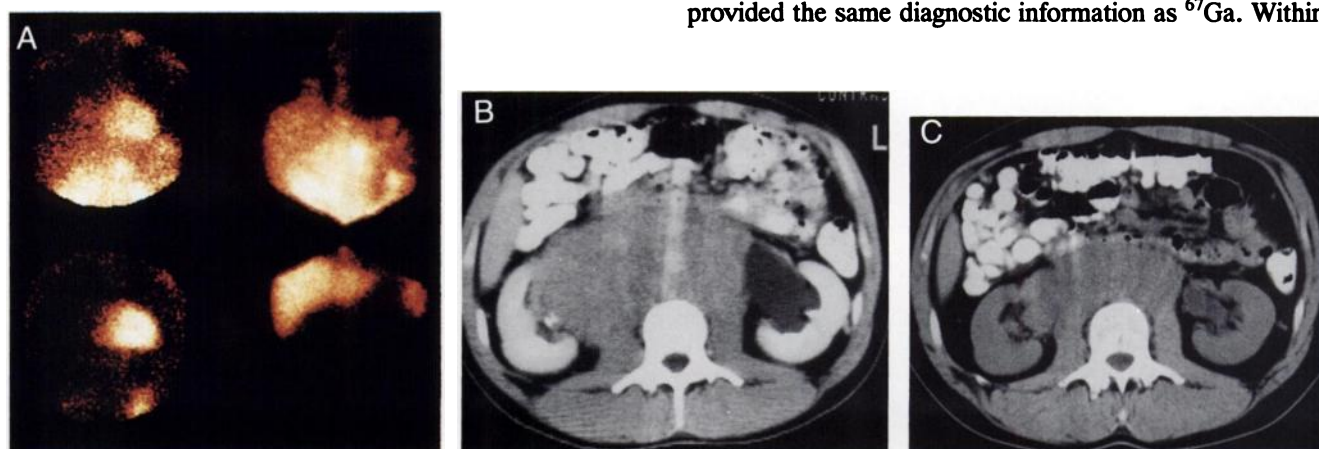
(A) Planar views of upper abdomen/thorax show similar FDG (top, left) and ⁶⁷Ga (top, right) uptake in retroperitoneally relapsed Hodgkin's disease (B, pretreatment CT at the renal pelvis level). Planar views of upper abdomen/thorax show similar intrapulmonary uptake (right, paracardially) indicated vital tumor tissue in a lesion previously considered to be residual fibrotic tissue. After two chemotherapeutic courses, tracer uptake was near normal (FDG, bottom left; ⁶⁷Ga bottom right), thus predicting volume response (C, CT after four courses at the same level as in B). FDG accumulation in the left part of the abdomen represents urinary stasis in the left kidney. This patient was classified as a partial remission on morphological grounds.
